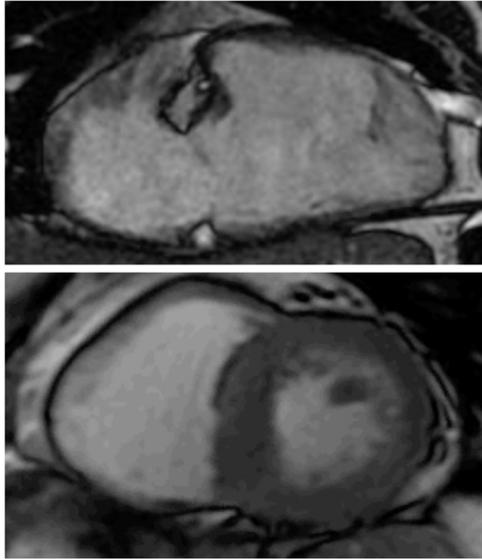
MRI look on the anatomy of the RV- inflow tract, trabeculated apex, outflow tract (infundibulum)
